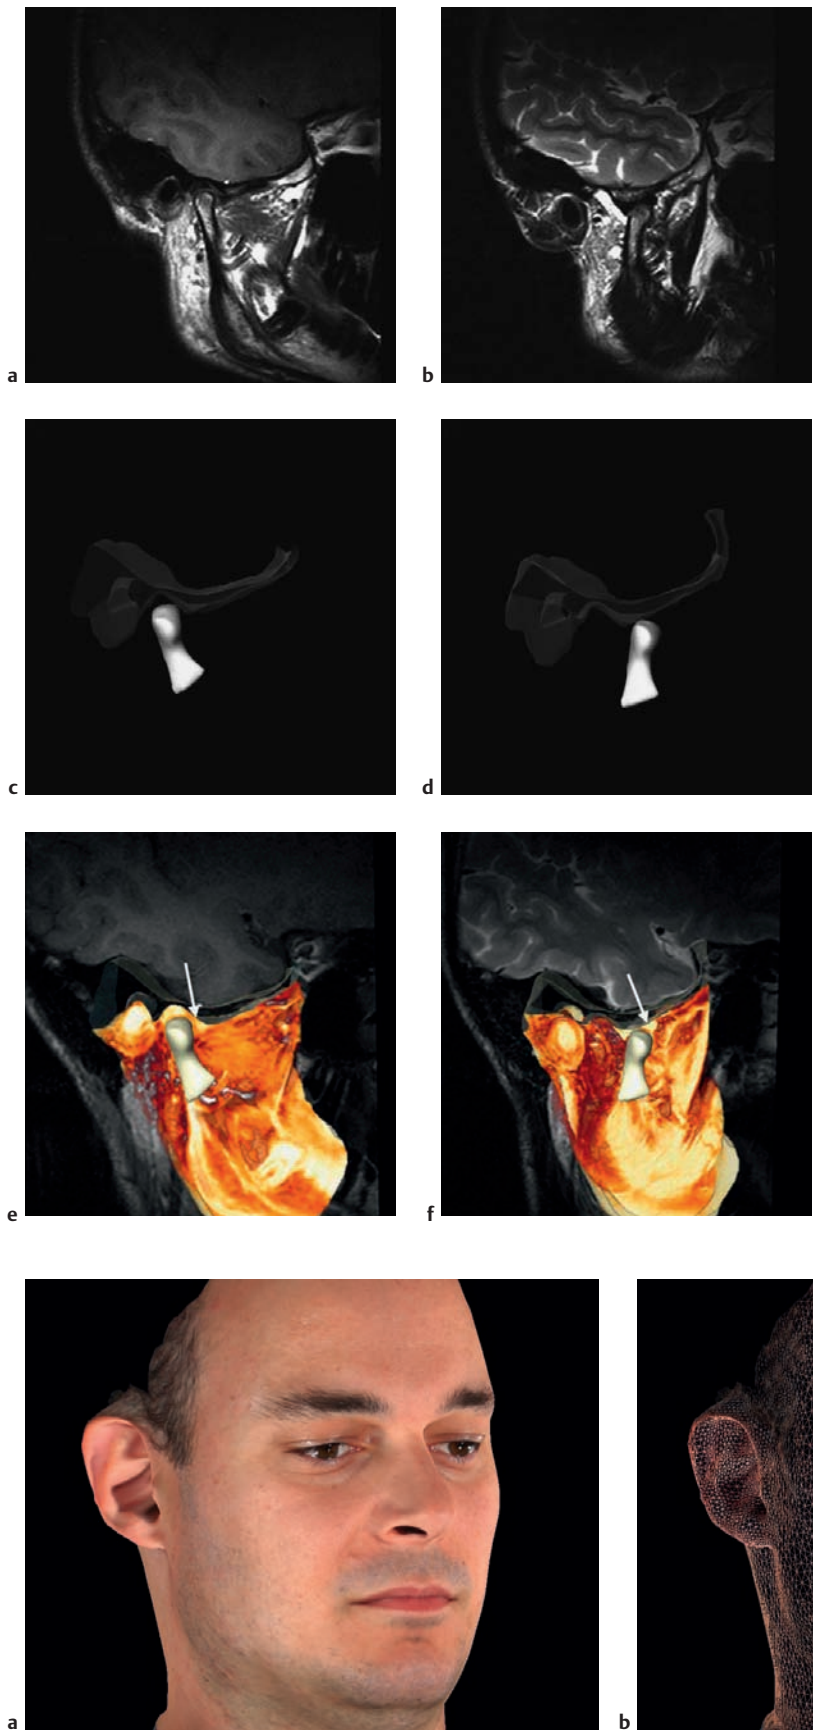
Three-dimensional reconstruction of magnetic resonance images for improved visualization of articular disk displacement. The raw scan (a, b) was modified using Amira 4.0 (Mercury Computer Systems) to focus on the condyle (c, d) as well as allowing visualization of the articular disk and the surrounding muscles (e, f). The conventional tomographic images remain readily available for comparative purposes.^{2–4} The images were kindly provided by Prof. Kober and Prof. Kinzinger.
